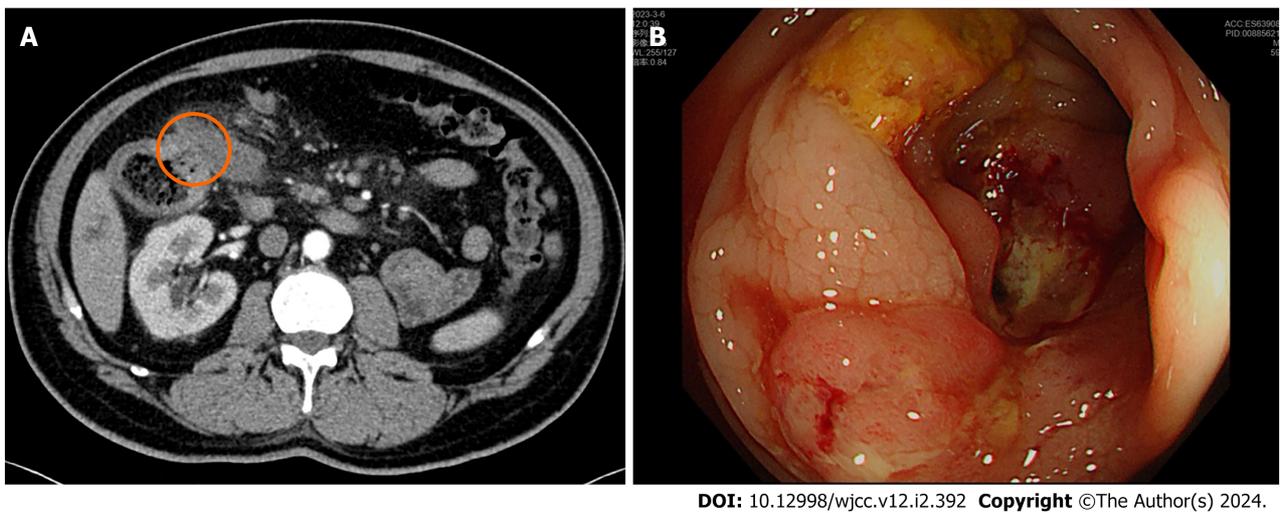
Computed tomography of the abdomen and colonoscopy examination. A: A tumor of the ascending colon (orange circle); B: A tumor in the descending colon.
